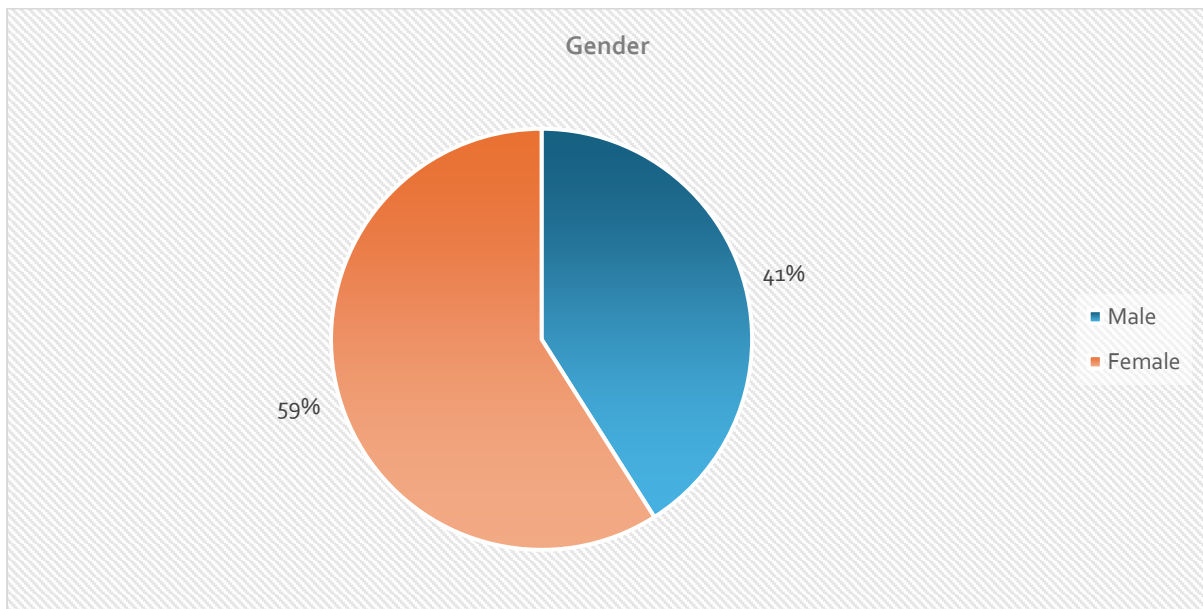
TIF MRI patient survey: patients' gender
